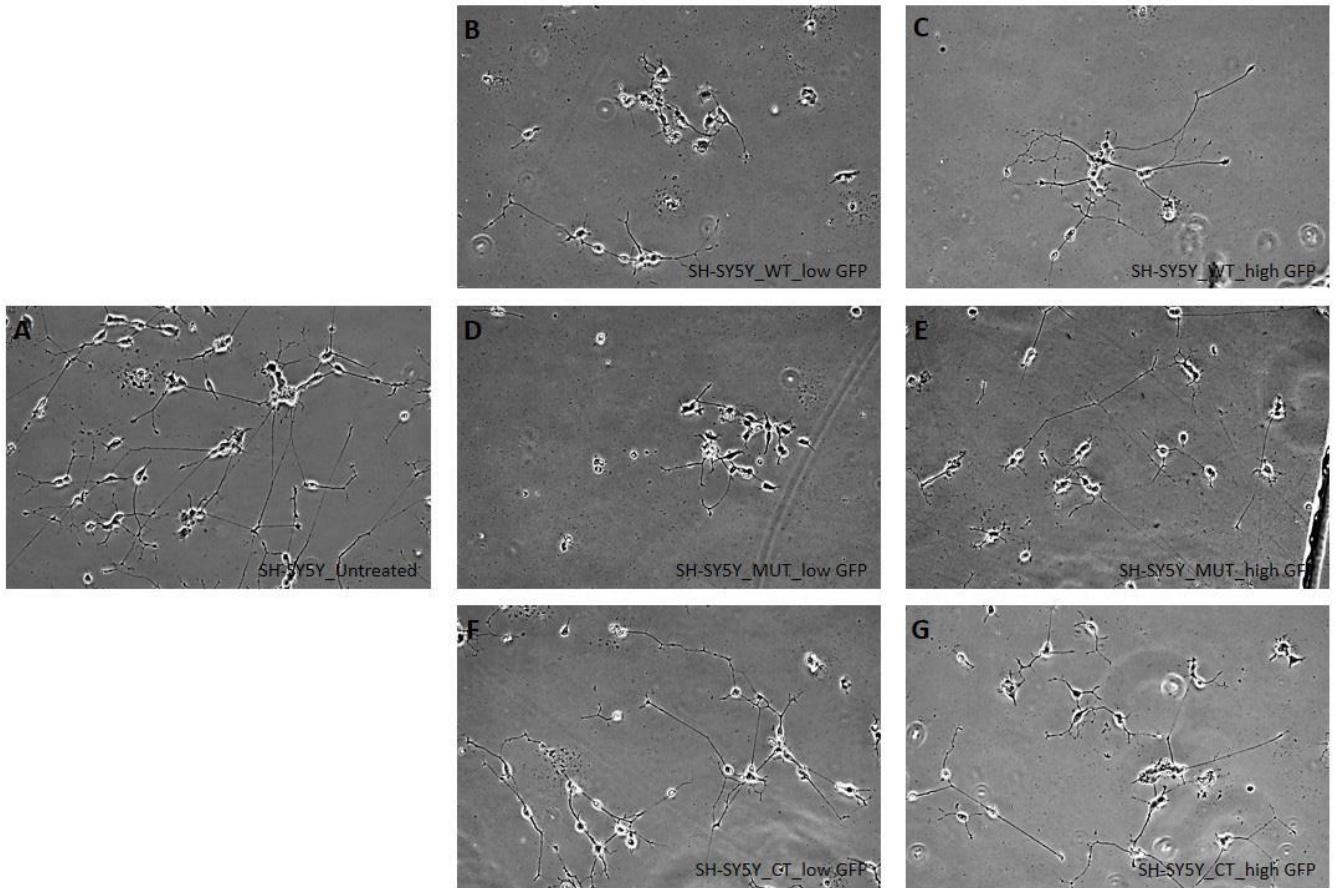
Images took at day 5 of differentiation in untreated SH-SY5Y cells (A), SH-SY5Y cells transduced with wild-type vector with low GFP expression (B) and high GFP expression (C), SH-SY5Y cells transduced with mutant vector with low GFP expression (D) and high GFP expression (E) and SH-SY5Y cells transduced with CT vector with low GFP expression (F) and high GFP expression (G)
